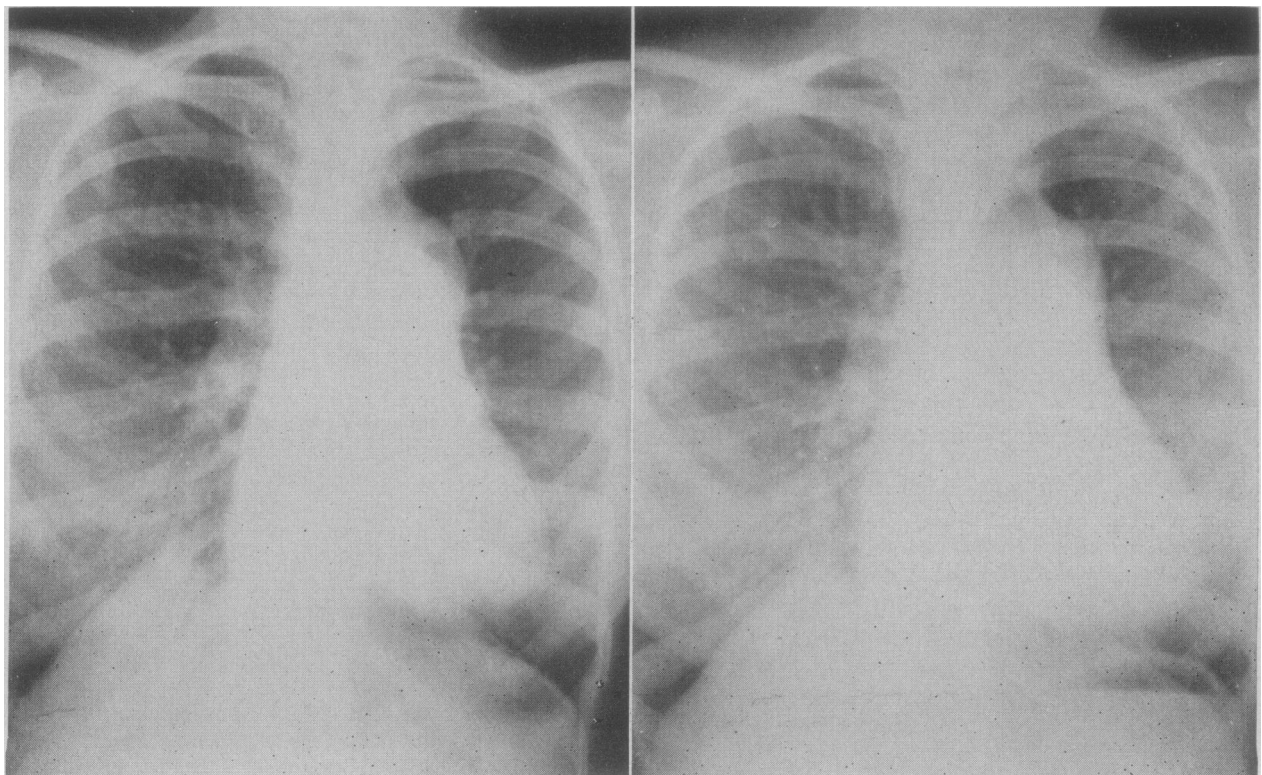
Chest roentgenograms before (on the left) and after (on the right) this patient's subacute bacterial endocarditis. Note the spinal scoliosis and the prominent pulmonary arteries.
